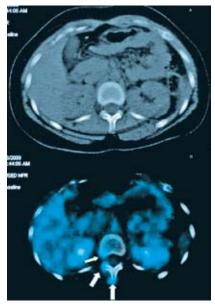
Axial projection of 12th vertebra, low dose CT (A), fused PET/CT (B) shows increased focal ¹⁸F-FDG activity on the lytic lesions located in the right posterolateral corpus (thin arrow), transverse and spinous processes (thick arrows).
